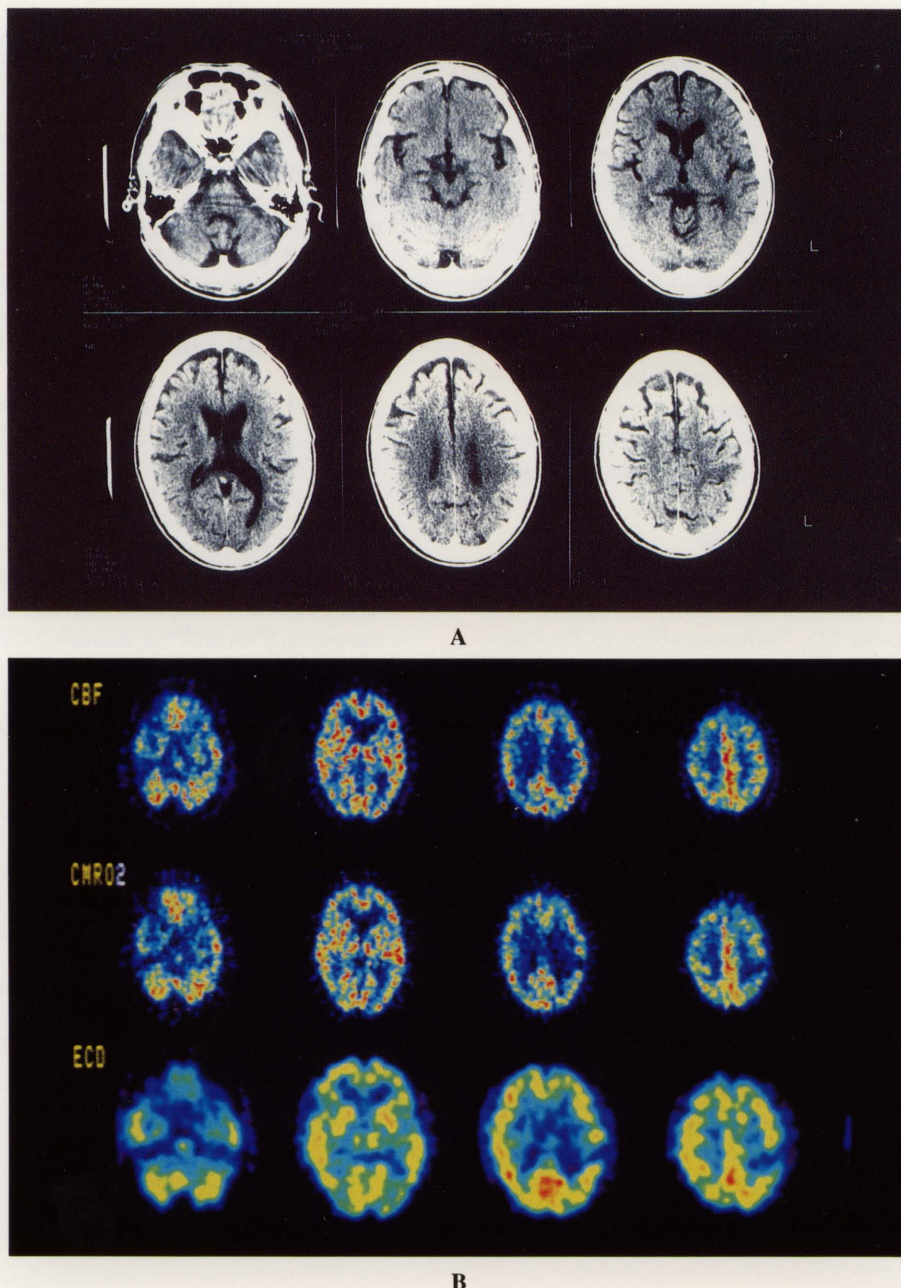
Computed tomography (CT) (A) and CBF, CMRO₂, ECD-SPECT and HMPAO-SPECT images (B) in a 59-year-old man with subacute cerebral infarction (Patient 3) comparable to the left parietal symptoms. PET, ECD-SPECT and CT were performed 20 days after the onset. CT revealed a faint LDA in the responsible left parietal lobe. The CMRO₂ and ECD-SPECT images showed a focal defect in the same region, whereas the CBF images revealed no significant defects in the lesion. The ECD-SPECT image resembles those of CMRO₂.
